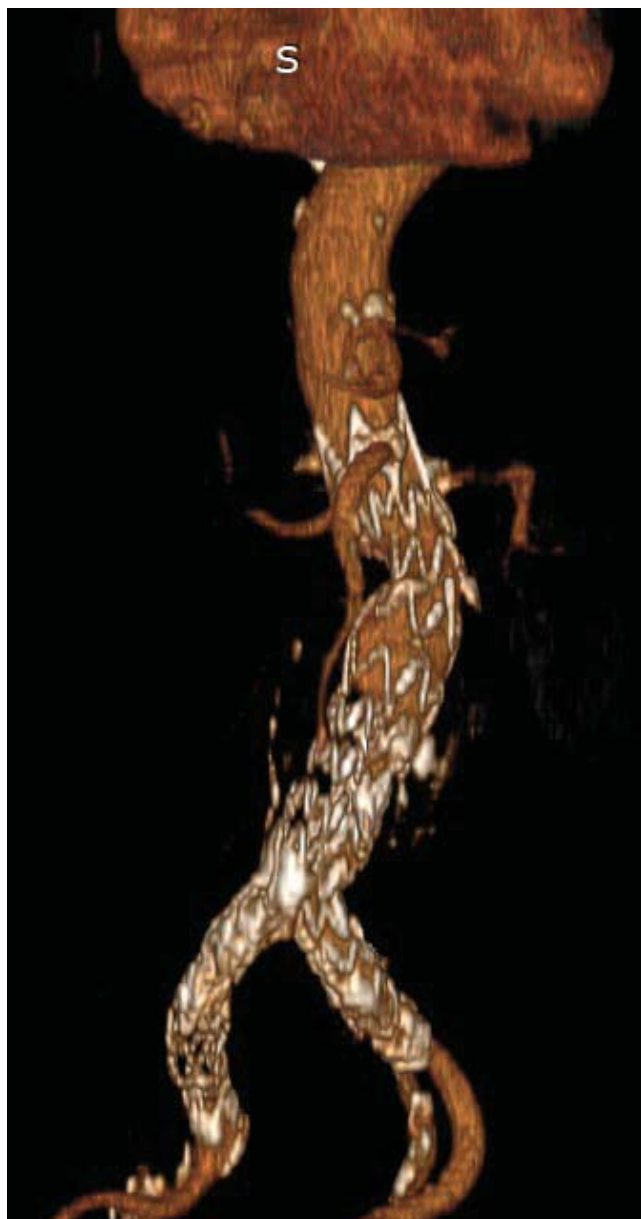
CT reconstruction - lack of loading with contrast substance in the right limb and right extension of the prosthesis.
